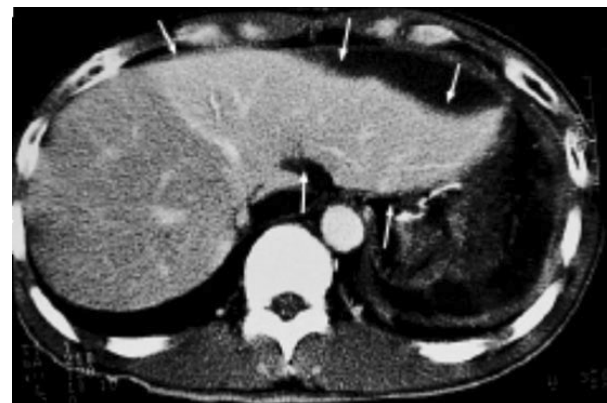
Multidetector computed tomography scan: transient hepatic attenuation difference.
